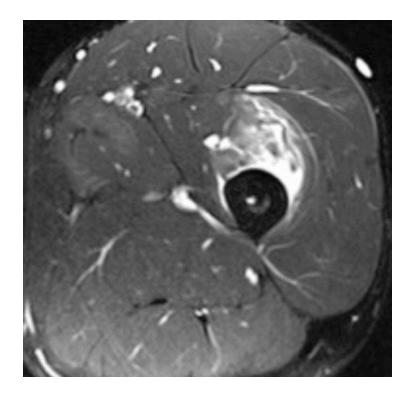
Axial fat-suppressed T2-weighted MRI of right proximal thigh shows severe muscle contusion of the vastus intermedius
